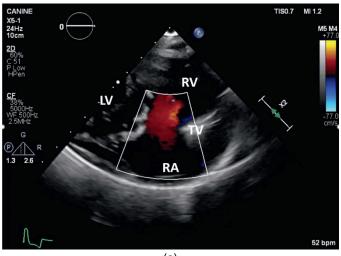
The apical 4 chamber view is sometimes a good plane to record diagnostic color flow through the tricuspid valve. More often, however, a foreshortened 4 chamber view is better. Here Video 2.32 diastolic upward flow through the tricuspid valve is red. This flow is typically not aliased since trans tricuspid flow is generally low velocity in the normal heart.
